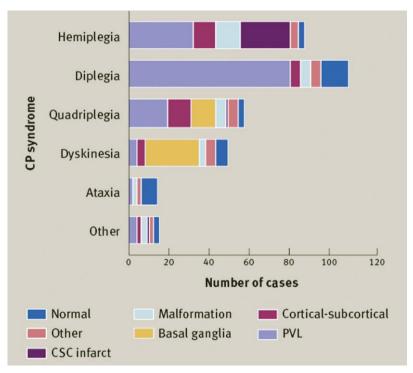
Periventricular leukomalacia (PVL) is one type of white matter damage of immaturity and was the most common MRI finding in spastic CP (Eunson et al. 2016).
